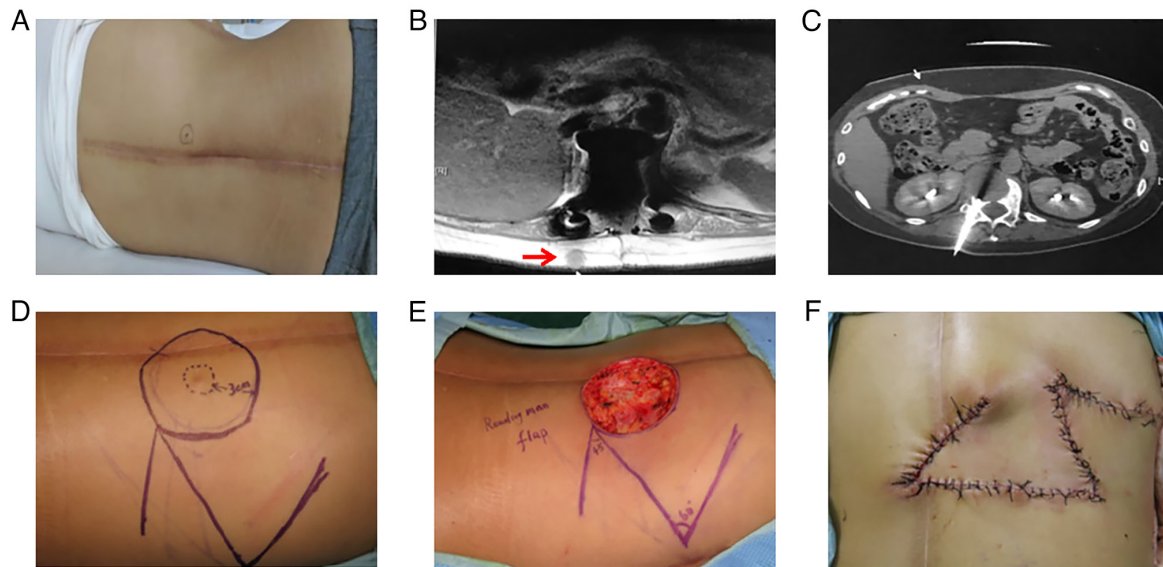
A subcutaneous nodule was detected 2 months after the index operation. (A) The nodule emerged near the incision. (B) Magnetic resonance imaging revealed the nodule. (C) The path of biopsy needle prior to the spinal surgery. (D) The surgery planning of radical lesion resection. (E) The nodule was radically removed. (F) A flap transposition surgery was subsequently performed.
